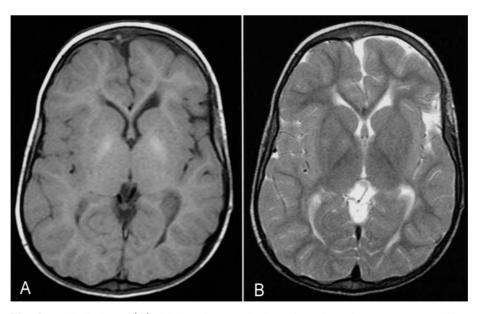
MRI findings. (A) Slightly increased signal intensity of both globus pallidus areas of basal ganglias on a T1-weighted image. (B) Multifocal high signal intensity and thinning of both periventricular deep white matter on a T2-weighted image.
